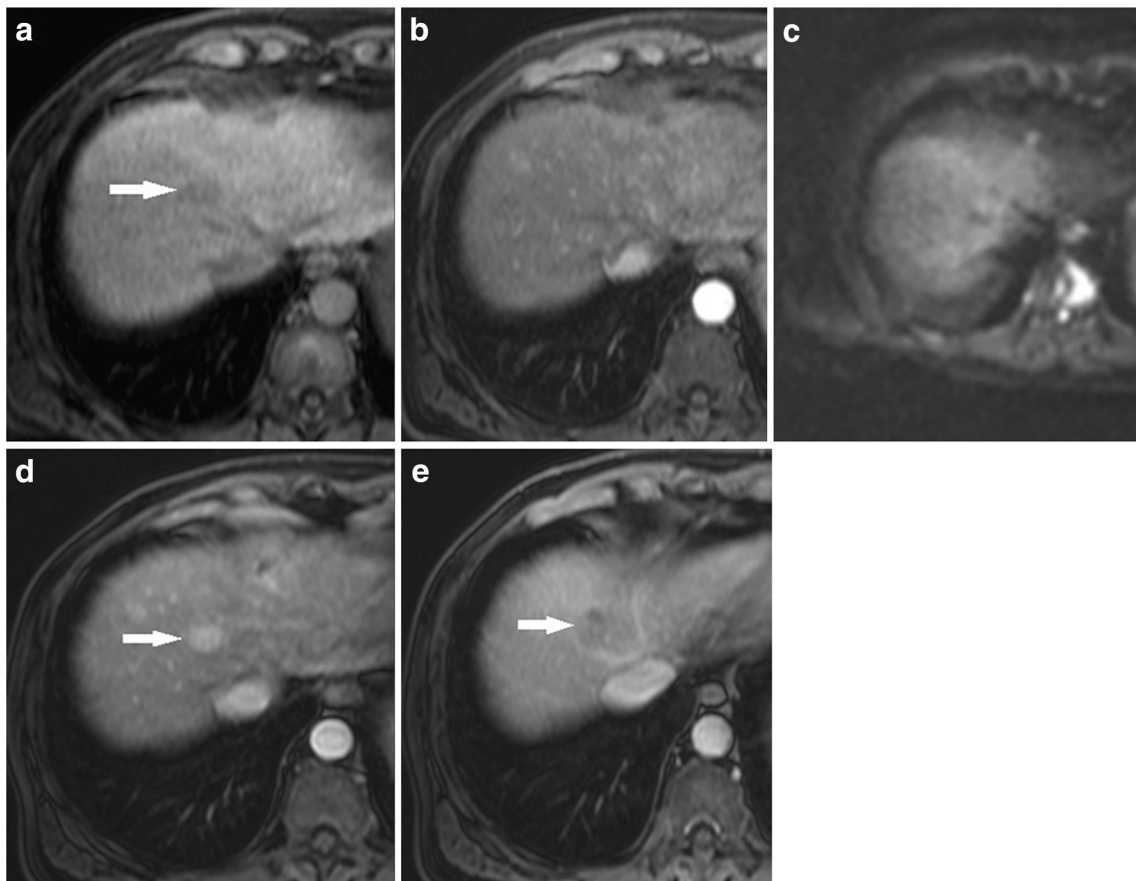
MR images of hepatocellular nodule that progress to hypervascular HCC in a 68-year-old woman with hepatitis C virus-related cirrhosis (a). Axial gadoxetic acid-enhanced 20-min HBP image demonstrates a hypointense nodule (*arrow*) not showing arterial enhancement in arterial phase image (b). Axial single-shot echo-planar
